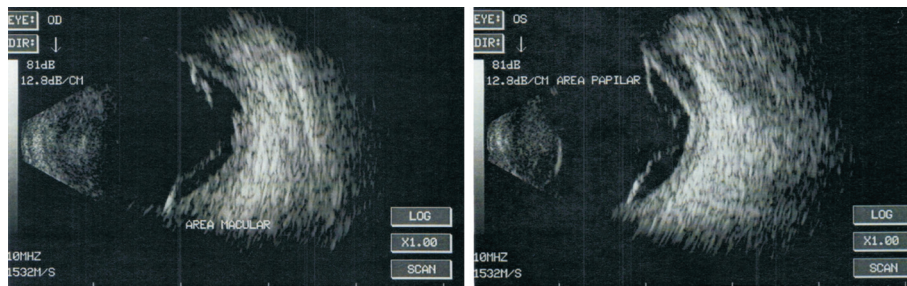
Ocular ultrasonography Total serous retinal detachment. No retinal tears and 360° choroidal detachment OU.
